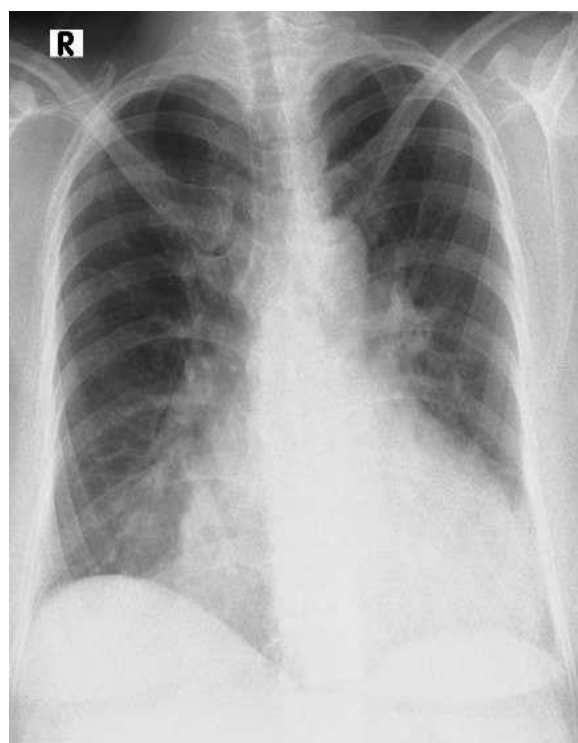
Chest X-Ray showed Cardiomegaly
